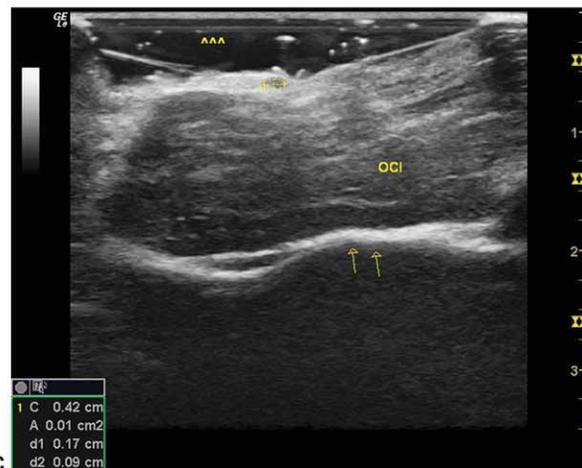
Sonogram of greater occipital nerve and obliquus capitis inferior muscle (OCI). The probe is placed along the long axis of the OCI muscle. GON, greater occipital nerve; SC, splenius capitis; SSC, semispinalis capitis; TR, trapezius. Arrows point to the lamina of C2. The ellipse outlines the cross-sectional area of the greater occipital nerve.
